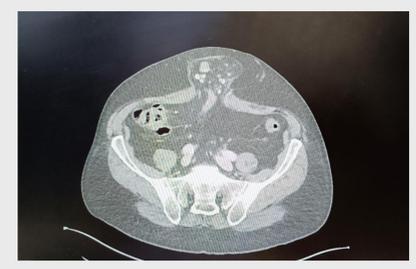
CT: Anatomical location: mid abdomen, above largest inferior hernia (Sac content: fat only)
